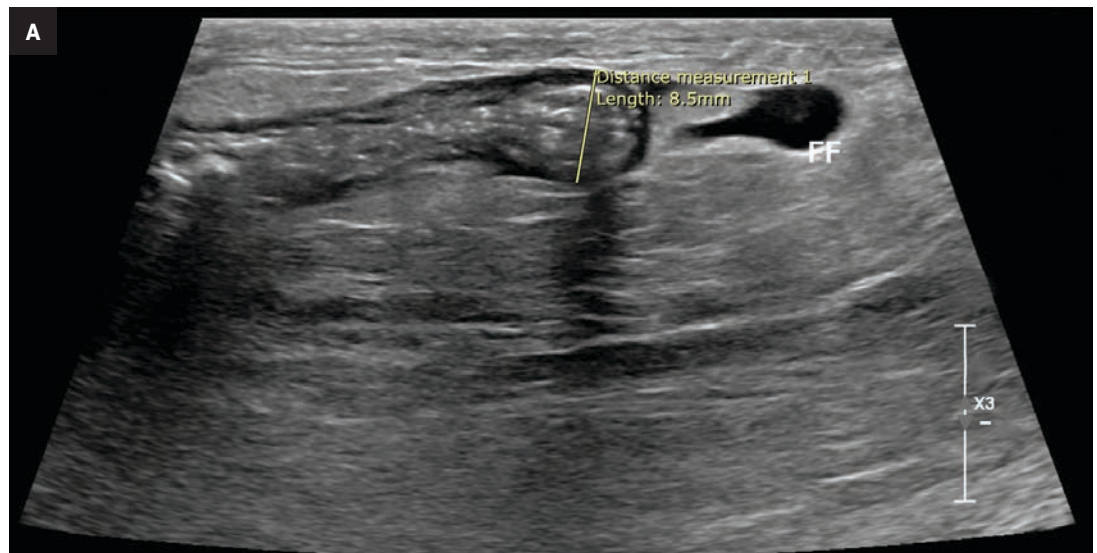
(A) Sagittal grayscale ultrasound of the right inguinal canal demonstrates a blind-ending tubular structure measuring approximately 9 mm consistent with a mildly dilated appendix. (B) Sagittal ultrasound with color of the right inguinal canal demonstrates a blind-ending tubular structure with increased peripheral color flow.
